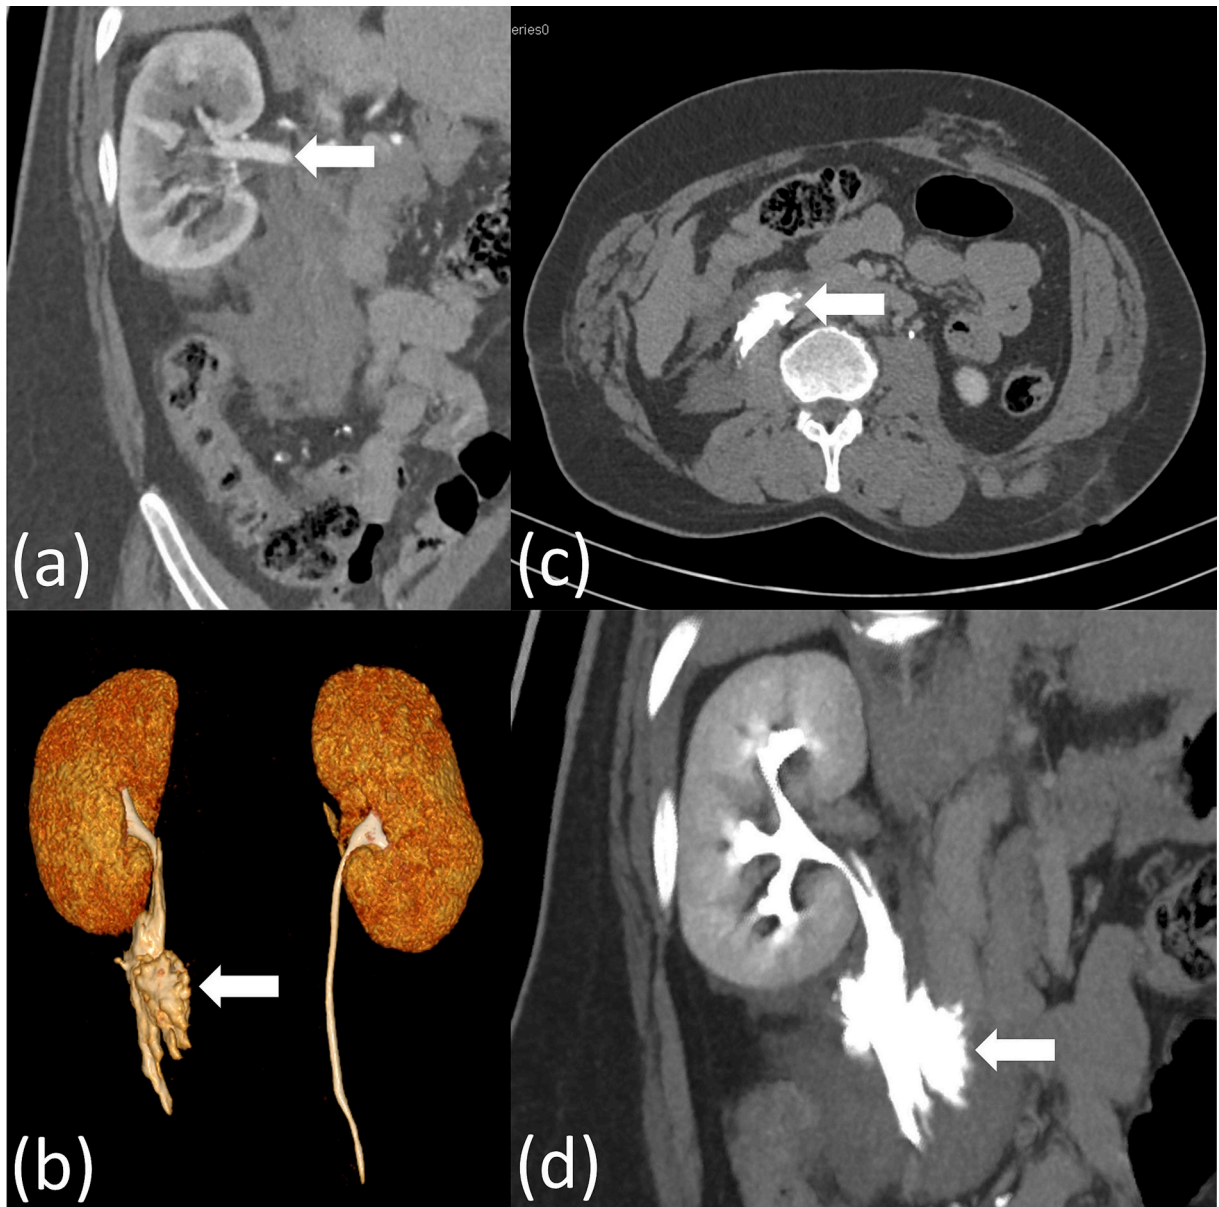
Computed tomography showcasing a complete disruption of the right proximal lumbar ureter: (a): axial portal image (arrow: discontinuity of the proximal right ureter). (b): 3D reconstruction. With late-stage extravasation of iodinated contrast material (arrow) (c): axial view. (d): coronal view.
